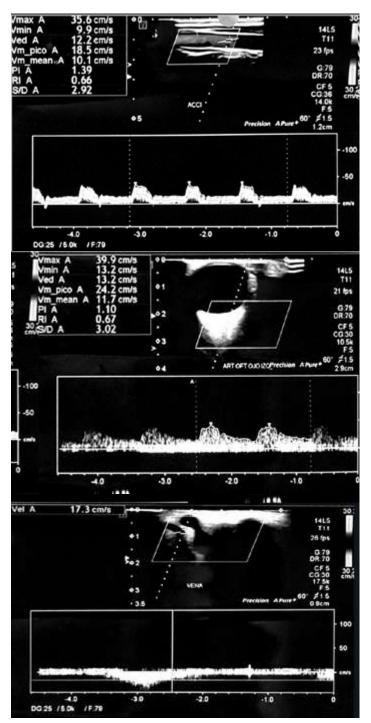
Venous doppler ultrasound of left upper eyelid
